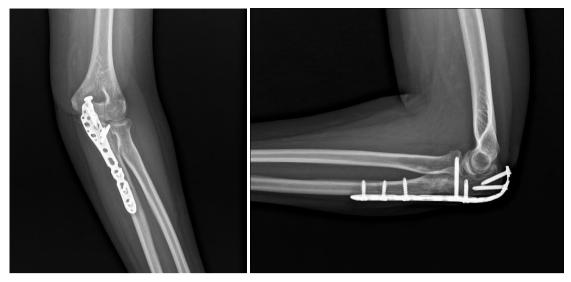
X-ray - 6 months follow up
